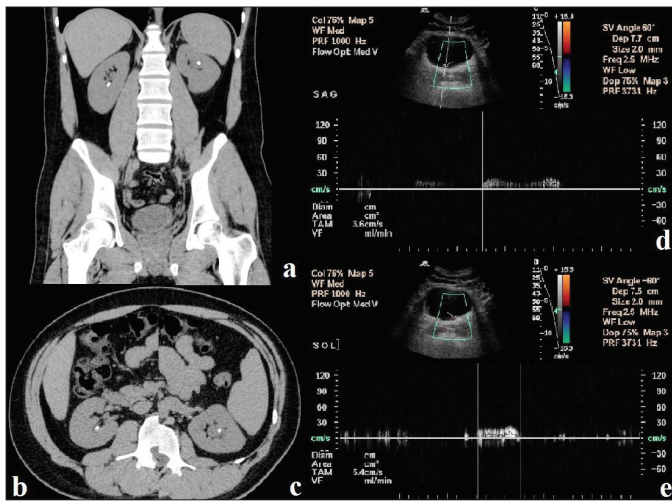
a) Bilateral kidney stones; b) <1 cm non-obstructive lower pole stone in right kidney and; c) <1 cm non-obstructive upper pole stone in left kidney stone of the patient on non-contrast computed tomography images; d) the ureteral jet flow of right ureter in the patient; JETave (3.6 cm/sec), JETtime (1.6 sec) and continuous JETpattern; e) the ureteral jet flow of left ureter in the patient; JETave (5.4 cm/s), JETtime (1 sec) and continuous JETpattern
